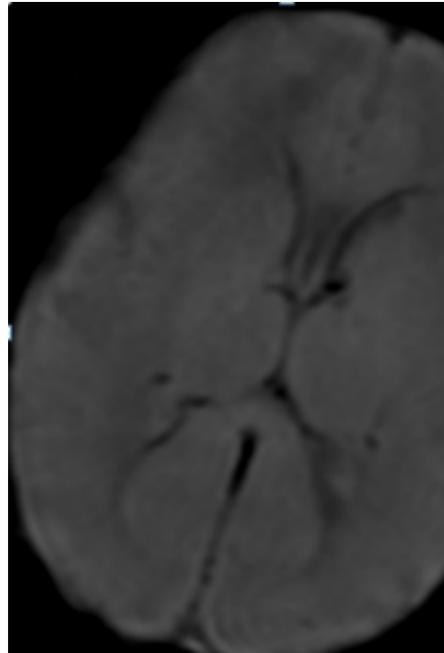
Axial SWI MR image showing blooming focus involving the left caudothalamic groove with ventricular extension, suggestive of GMH.
